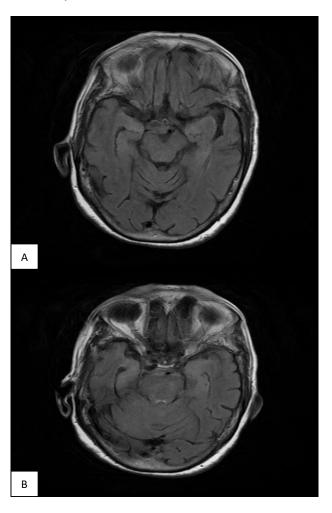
(A and B): MRI images indicative of FLAIR hyperintense signal suggestive of edema in the left lentiform nucleus and head of caudate nucleus.
